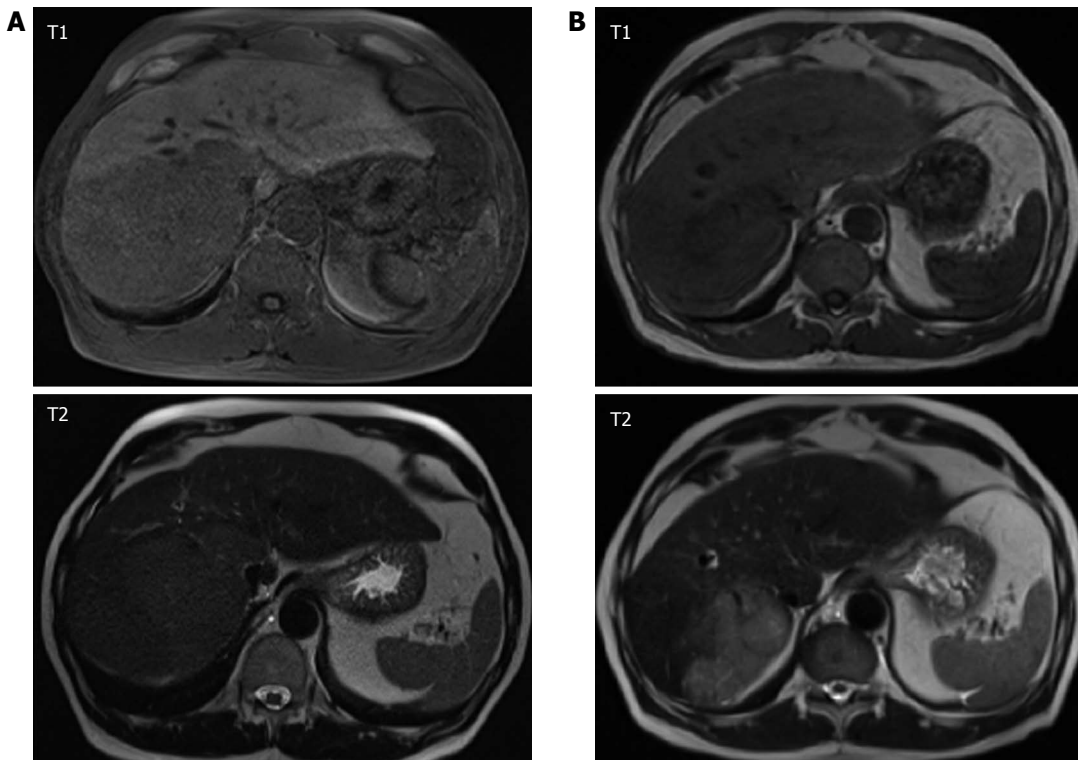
Dynamic gadolinium-enhanced magnetic resonance imaging (MRI; T1, T2 weighting), in a 67 year old patient with hepatocellular carcinoma evolved from liver cirrhosis due to hemochromatosis (A) before initiation of anti-angiogenic therapy and (B) after 70 d or three cycles of transarterial chemoembolization and continuous administration of sorafenib, respectively. Patient showed partial response according to RECIST criteria. Serum alpha-fetoprotein level decreased from 276 to 115 ng/mL.
